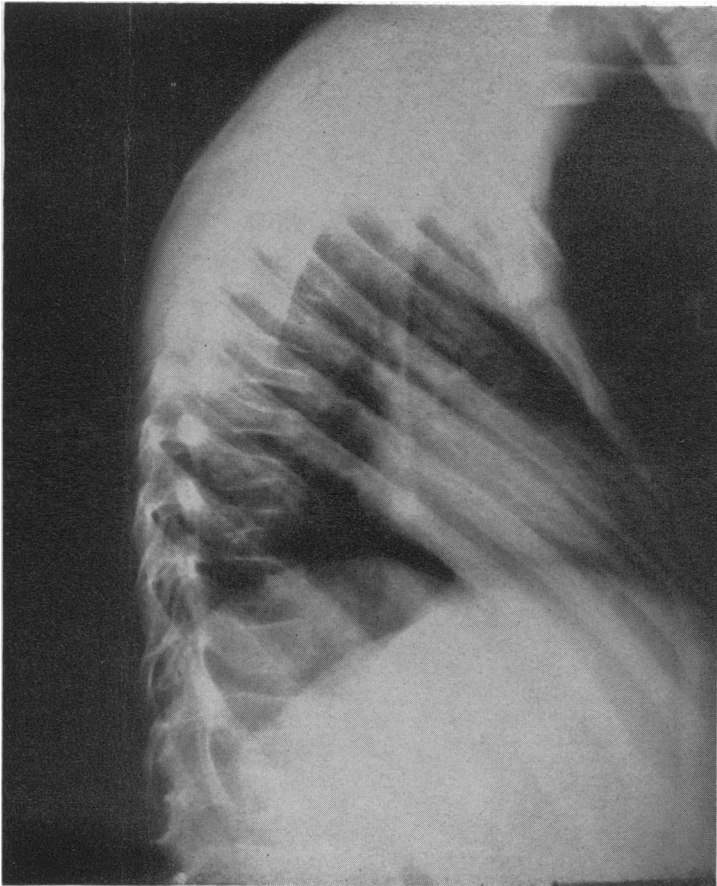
Radiograph of spine, showing collapse of vertebral bodies.
